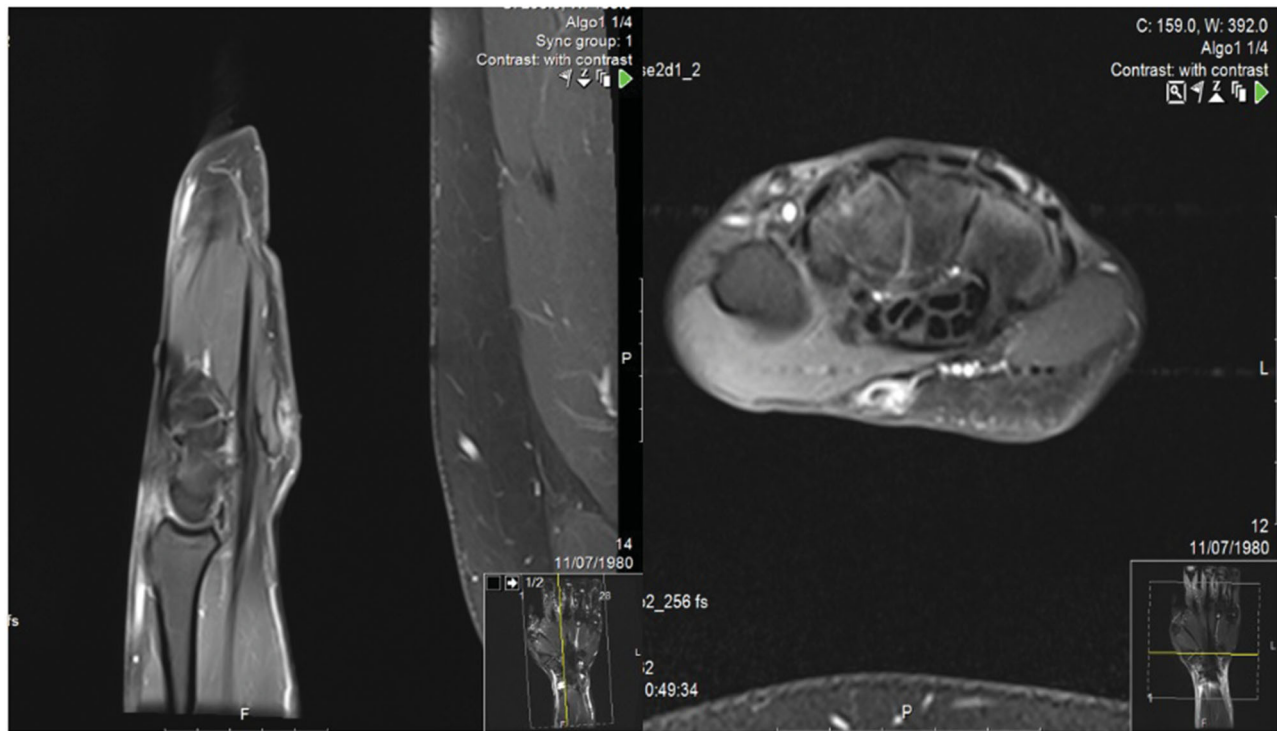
Sagittal (left) and axial T1-weighted MR images with contrast, presenting an epithelioid sarcoma (ES) lesion confined to the thenar region of the hand.
